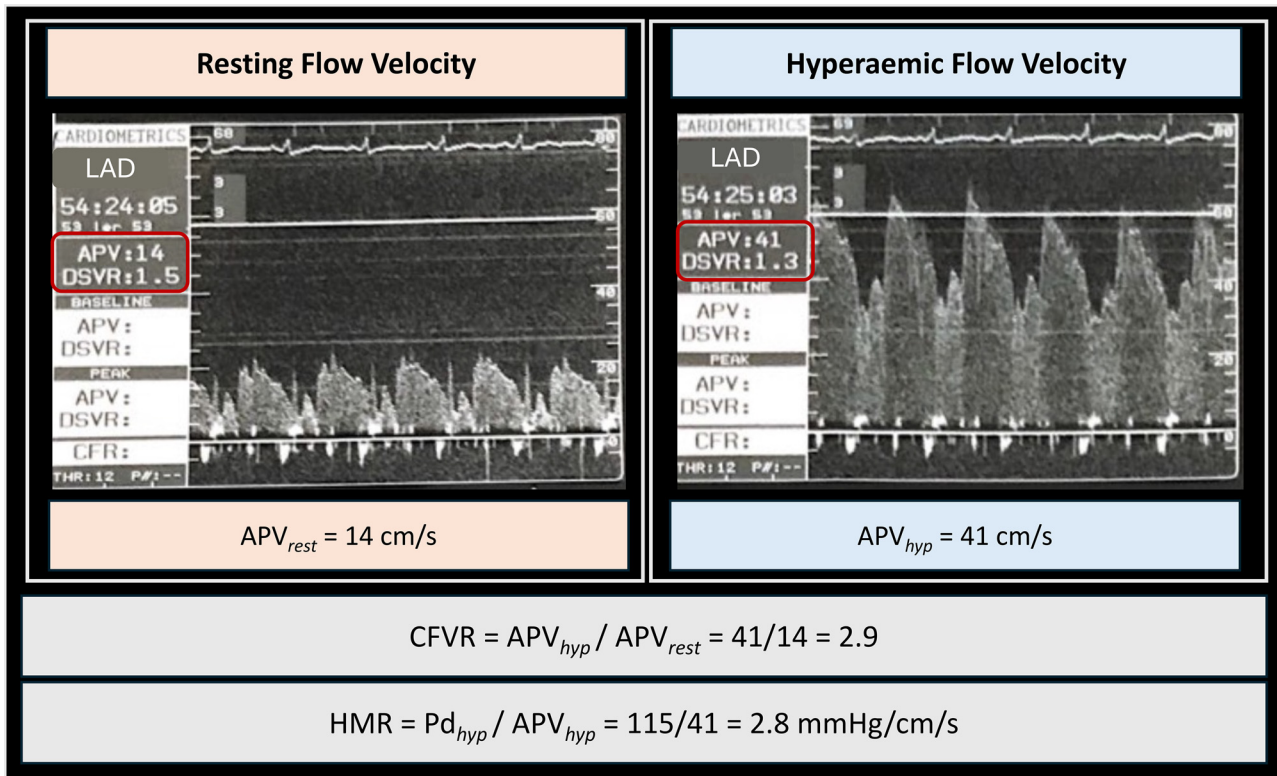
Intracoronary flow velocity measurement. Intracoronary flow velocity measurement: case example in the left anterior descending artery. A Doppler wire is placed in the coronary artery to be evaluated and connected to a dedicated console. Resting average peak velocity value in cm/s is displayed in real time (14 cm/s). After inducing hyperemia (intracoronary papaverine was used in this specific case), flow velocity increases up to an average peak velocity (APV) value of 41 cm/s. Coronary flow velocity reserve (CFVR) can be calculated as the ratio between hyperemic and resting APV (2.9). If simultaneous intracoronary pressure measurement is performed, hyperemic microvascular resistance (HMR) can be derived as the ratio between P_d and APV both measured during hyperemia, in mmHg/cm/s. APV_{rest} , average peak velocity at rest; APV_{hyp} , average peak velocity during hyperemia. Courtesy of Dr. Bernard De Bruyne.
